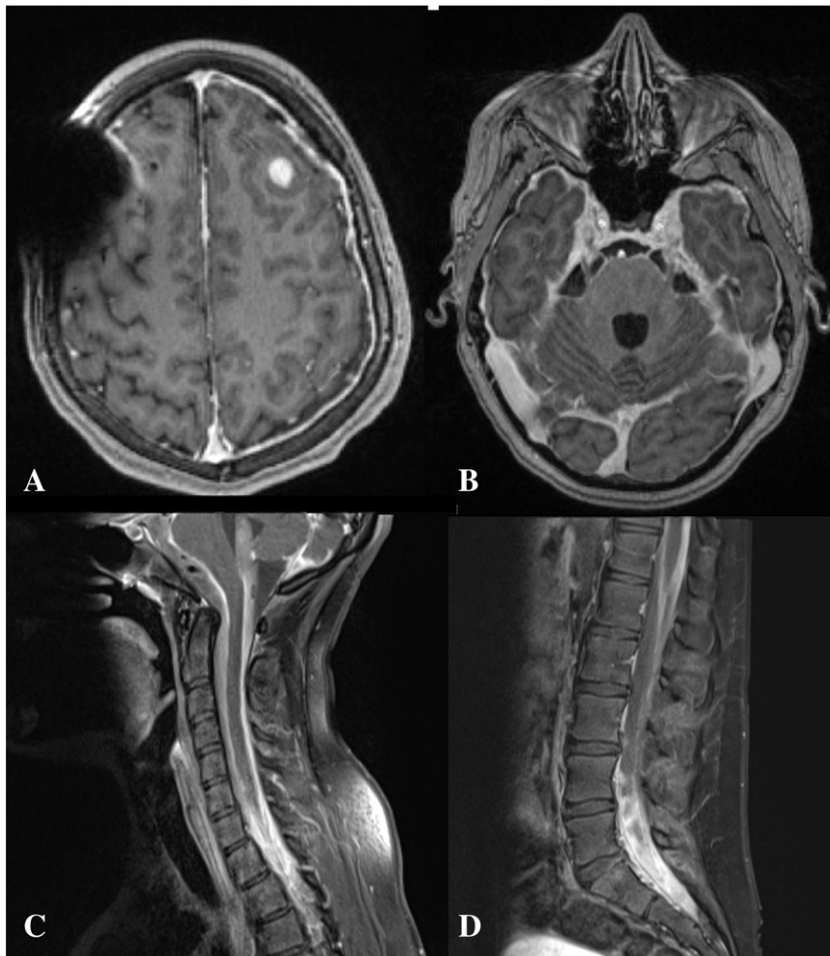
MRI of brain and spine. (A) Axial postcontrast T1 imaging of the brain showing postoperative sequelae of right frontal ventriculoperitoneal shunt placement and left frontal brain biopsy with increased leptomenigeal enhancement along the left parietal and frontal region. (B) Axial postcontrast T1 imaging showing prominent leptomenigeal enhancement in the subarachnoid spaces of the middle cranial fossa medial to the temporal lobes extending along cranial nerves V and VI. (C and D) Postcontrast T1 imaging of the cervical and lumbar spine showing interval increase in leptomenigeal enhancement along the spine on multiple levels.
